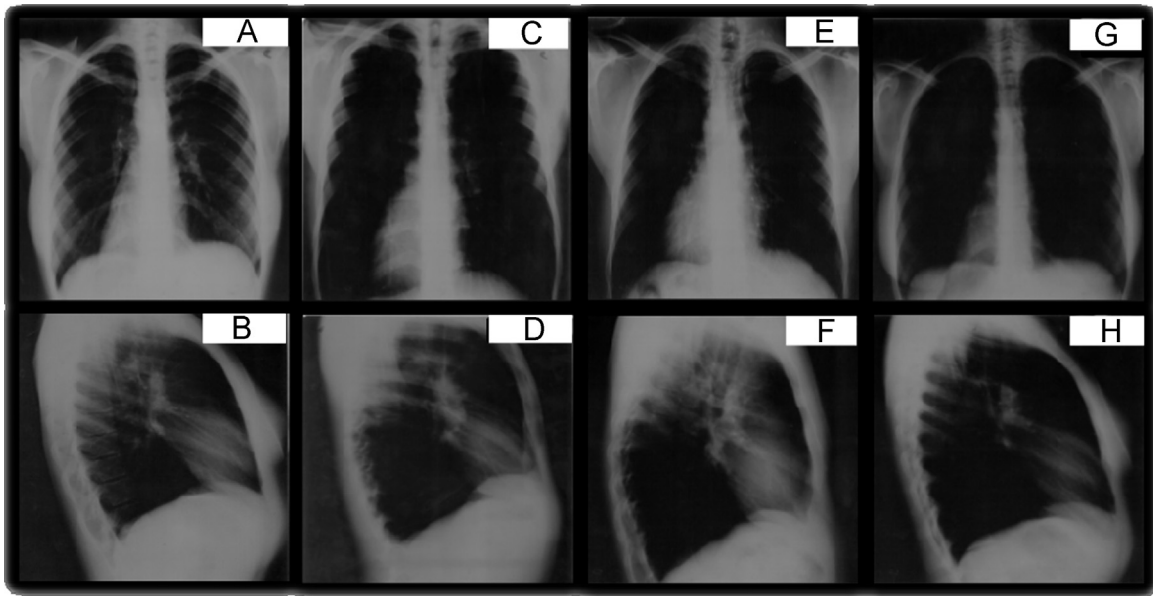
Researchers chest X-ray showing calcifications and nodular shadowing suggesting initial pulmonary infection of each research infected. A,B-Research 1; C,D-Research 2; E,F-Research 3; G,H-Research 4.
